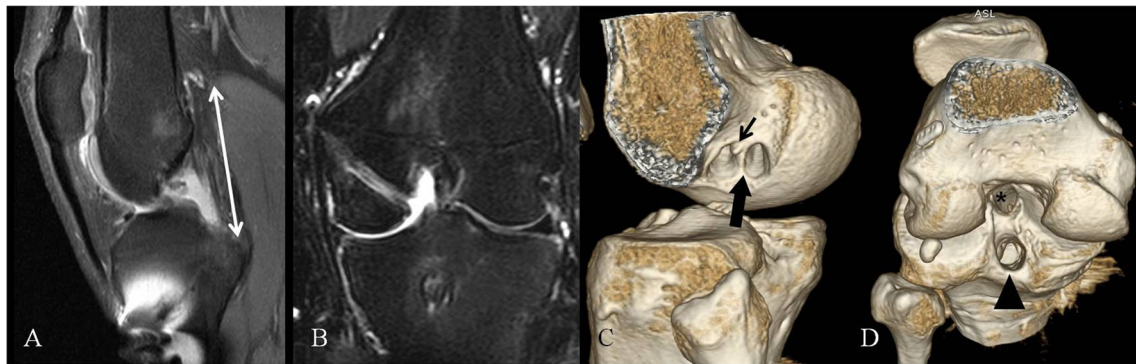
Chronic disruption of the graft. a Sagittal PD FS MRI and b coronal T2WI FS. No graft is identified in the intercondylar region, with fluid occupying the theoretical course of the graft. As an indirect sign of disruption, there is posterior displacement of the tibia (*arrow* in a). c MDCT 3D VR for new ligament plasty planning shows the intercondylar
